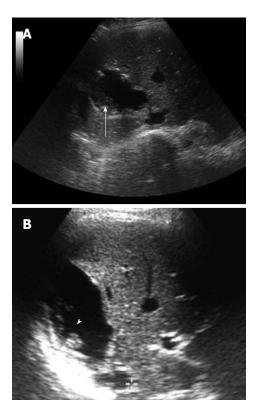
Liver hydatidosis in a 27-year-old female. Ultrasonography images (A, B) show a lesion with mixed echogenicity, with hydatid sand (the arrow) and multiple echogenic foci (the arrowhead).
